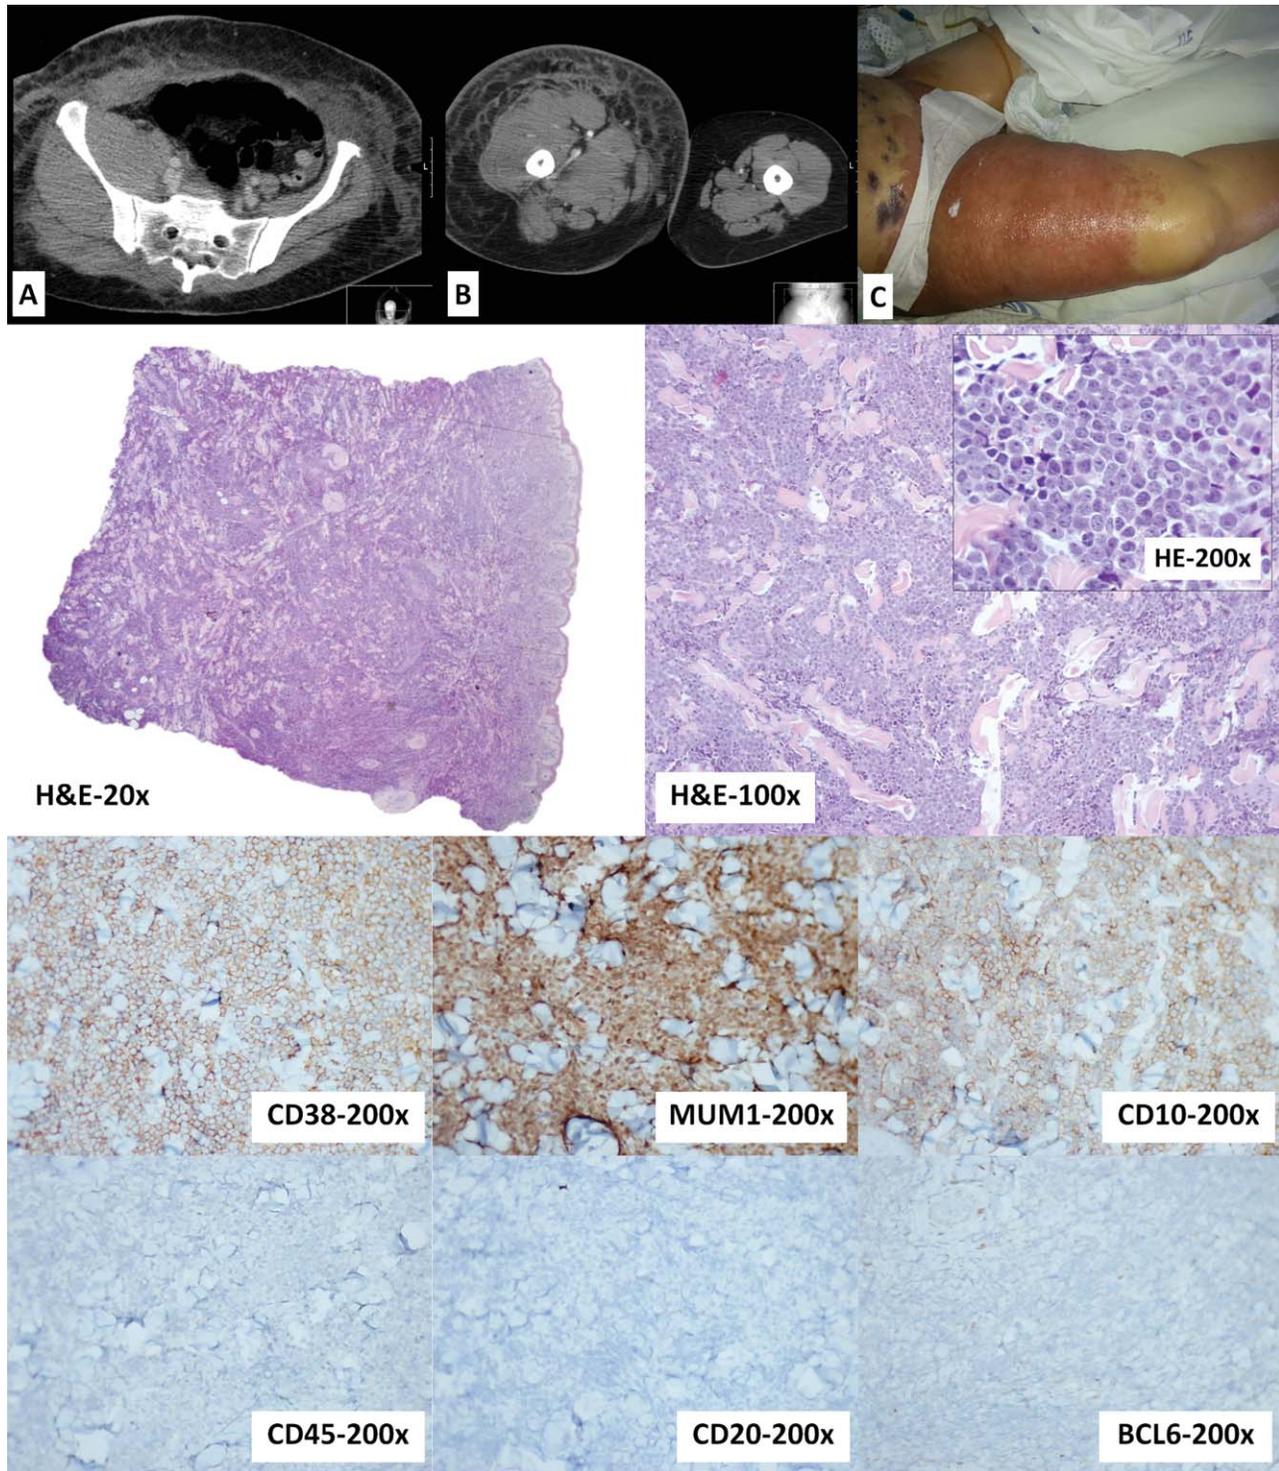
Upper panel: CT scan of the lower abdomen (A) and lower extremities (B), and picture of the patient's lower extremities few days before death (C). Lower panel: Skin biopsy from the abdominal region, showing diffuse infiltration by a medium to large cell population of cells with apparent cytoplasm, ovoid nuclei with prominent nucleoli, and frequent mitosis. These cells were positive for plasma cell marker CD38 and MUM1, and focally for CD10, in the absence of immunoreactivity for CD45, CD20, and BCL-6.
